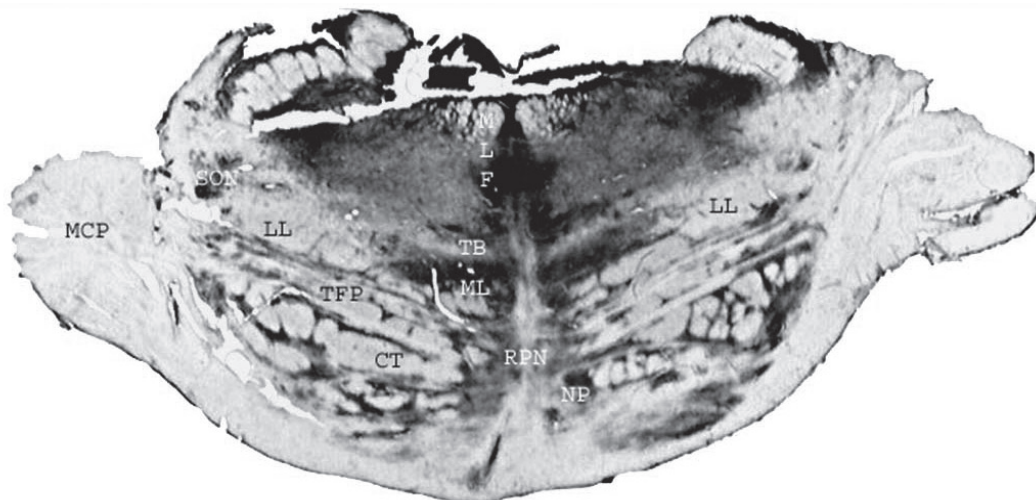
Cross section of the pons at the level of the trigeminal nerve. Middle cerebellar peduncle (MCP); Superior olivary nucleus (SON); Lateral lemniscus (LL); Transverse fibers of the pons (TFP); Corticospinal tract (CT); Medial longitudinal fasciculus (MLF); Trapezoid body (TB); Medial lemniscus (ML); Raphes pontine nuclei (RPN); pontine nuclei (NP)
